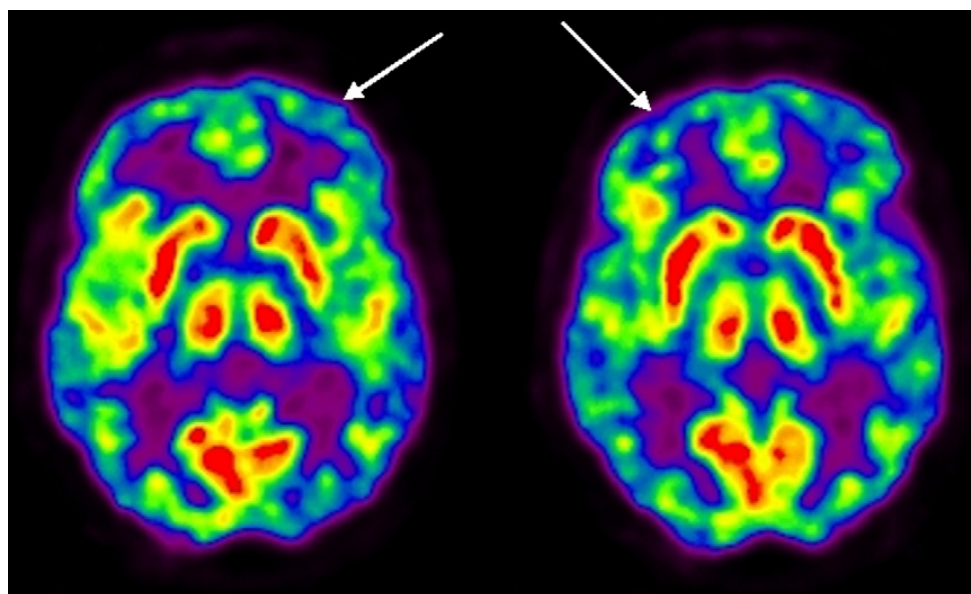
FDG-PET scan of patient with schizophrenia showing a mild global decrease, particularly in the frontal regions (arrows), consistent with some of the reported findings in the literature.
